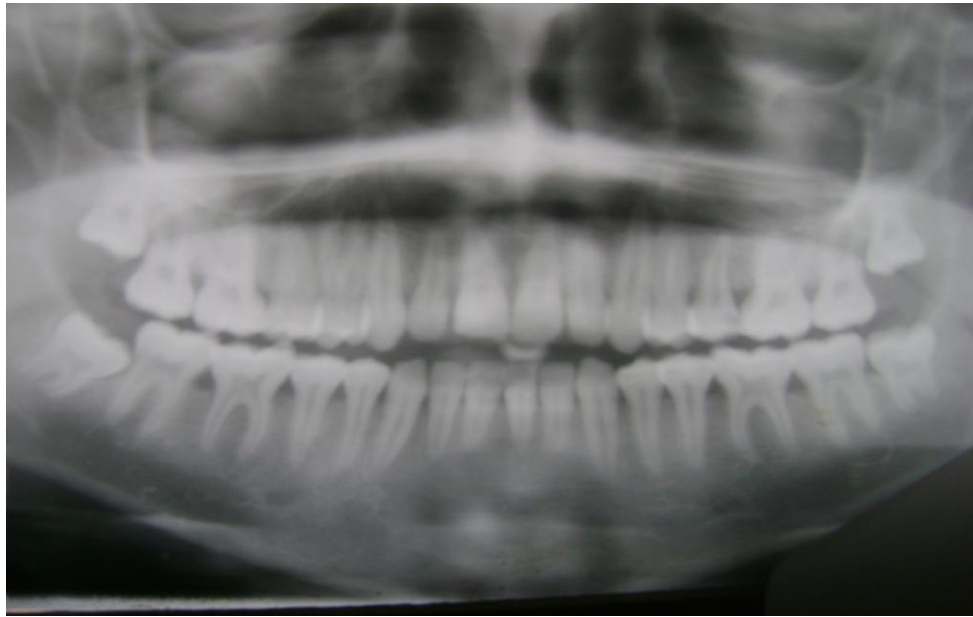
A panoramic radiograph showing the mental foramina at the level of 2<sup>nd</sup> premolar ,below the apices of premolars .
